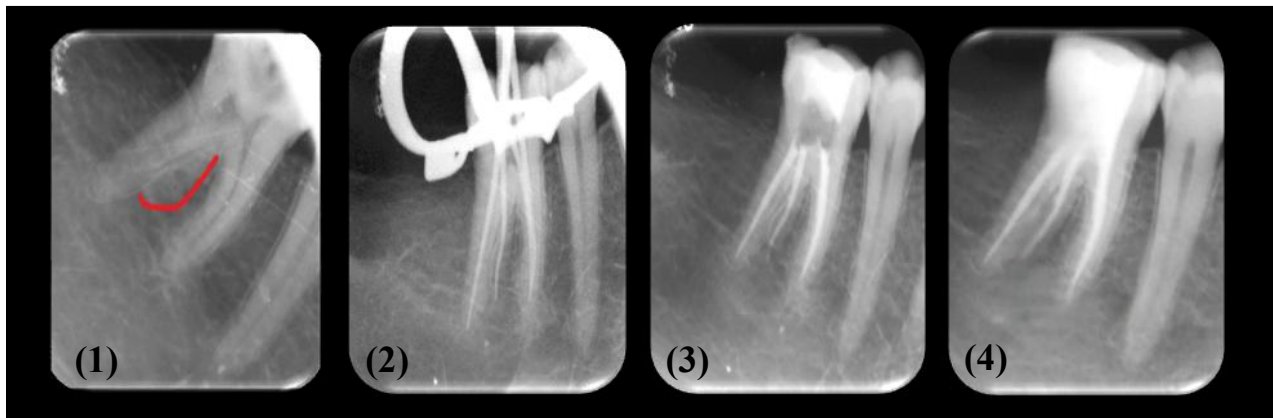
Preoperative radiograph of tooth 46
